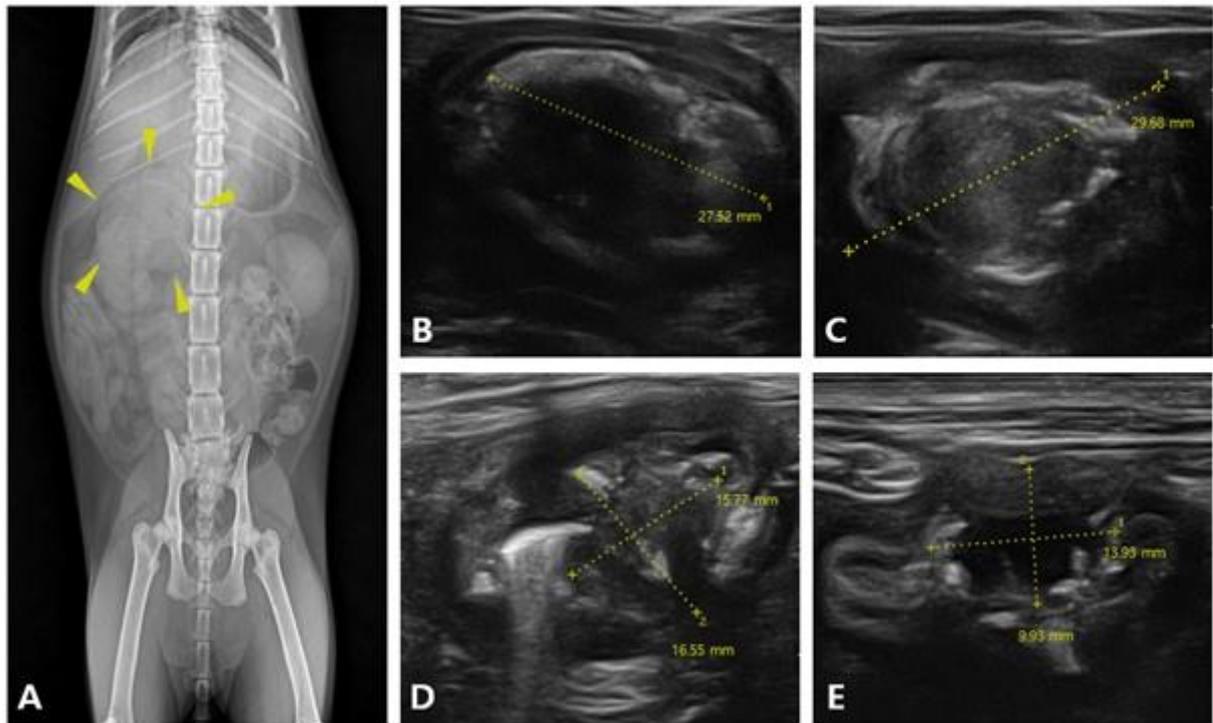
Radiographic and ultrasonographic evaluation of the lesion before and after treatment. (A) A single mass with soft tissue opacity was observed between the pylorus and duodenum. The mass had a length of two lumbar vertebrae bodies (yellow arrow head). (B) Ill-defined hypoechoic mass with relatively clear hyperechoic margination in the stomach. The length of the mass is indicated by the dotted line (27.52 mm). (C) Rough and hypoechoic mass with irregular hyperechoic border in the duodenum. The length of the mass is indicated by the dotted line (29.88 mm). Both (B) and (C) were measured at the first presentation and the mucosal and submucosal layers are lost, and the external muscle layer seems hyperplastic in both of ultrasonographic images. (D) Remaining mass with heterogenous echogenicity after partial resection of mass at pylorus. The length and diameter of the mass are indicated by the dotted line (15.77 mm × 16.55 mm). (E) Mass with decreased size 2 weeks after medical treatment. The length and diameter of the mass are indicated by the dotted line (13.99mm × 9.93mm)
